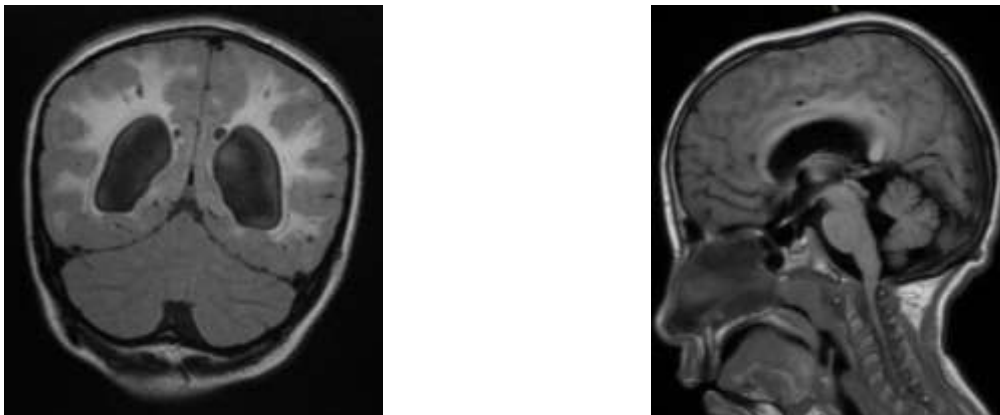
Coronal FLAIR weighted MR image of the brain: Symmetric periventricular white matter lesions, associated with mild ventriculomegaly (A). Sagittal T1-weighted MR image of the cervical spine: Large isointense soft-tissue mass surrounding the short odontoid process and the anterior arch of C1, determining substantial reduction of spinal canal caliber and consequent compression of the spinal cord (B).
